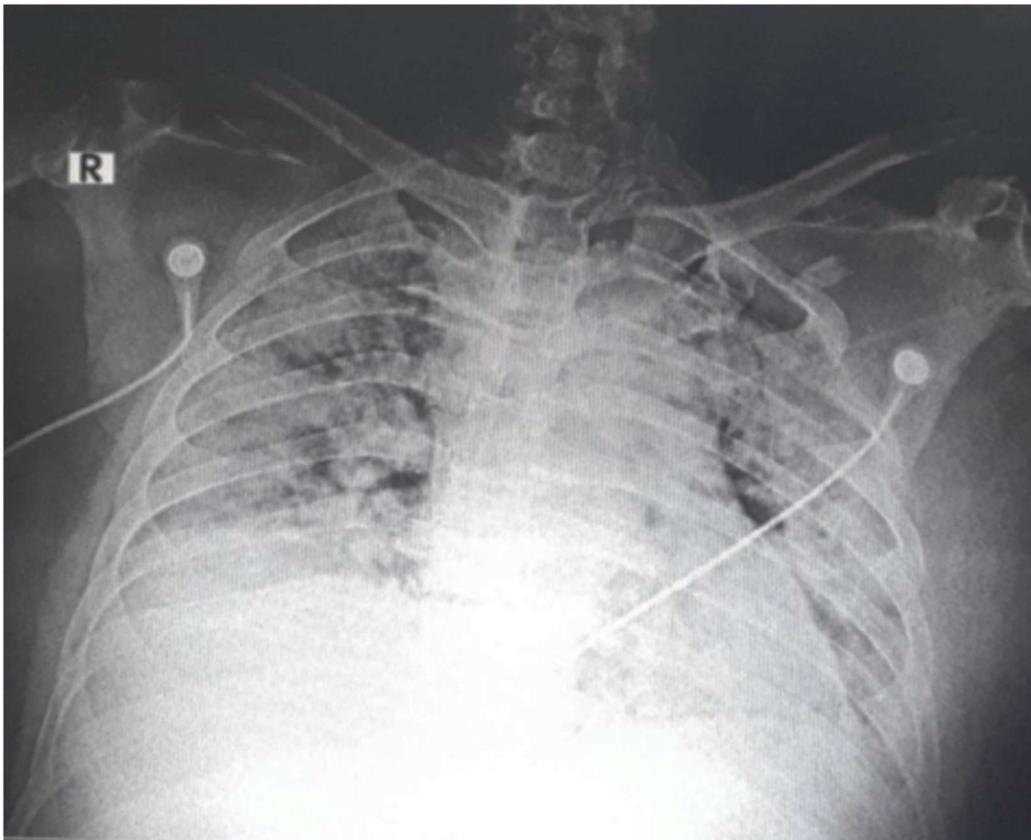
Baseline anterior-posterior view (AP) chest radiographs of case 1.
